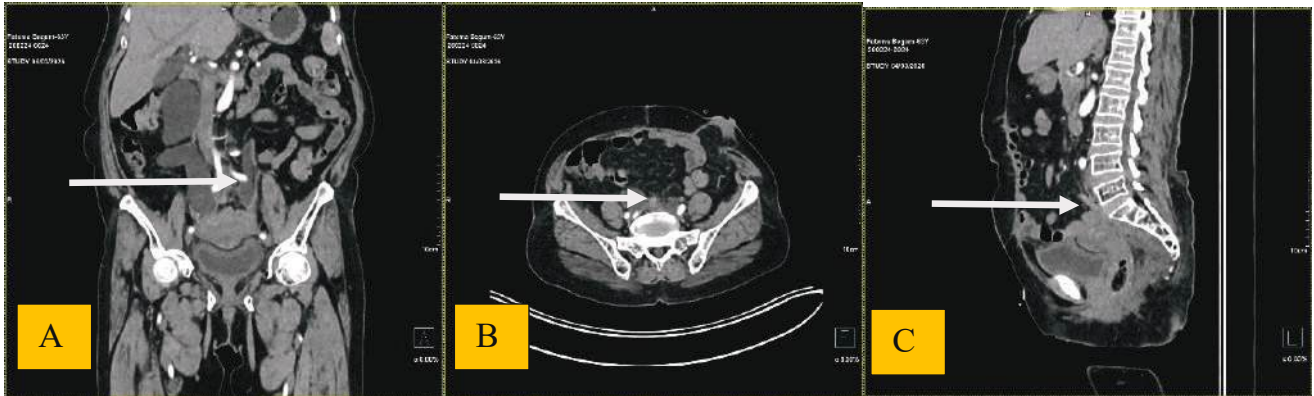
Contrast-enhanced CT images (Fig A: coronal, Fig B: sagittal and Fig C: axial planes) demonstrate markedly distorted pelvic anatomy due to post-surgical and post-radiation fibrosis, limiting evaluation. A definite thrombus is not identified; the observed structure more likely represents a pelvic lymph node.
